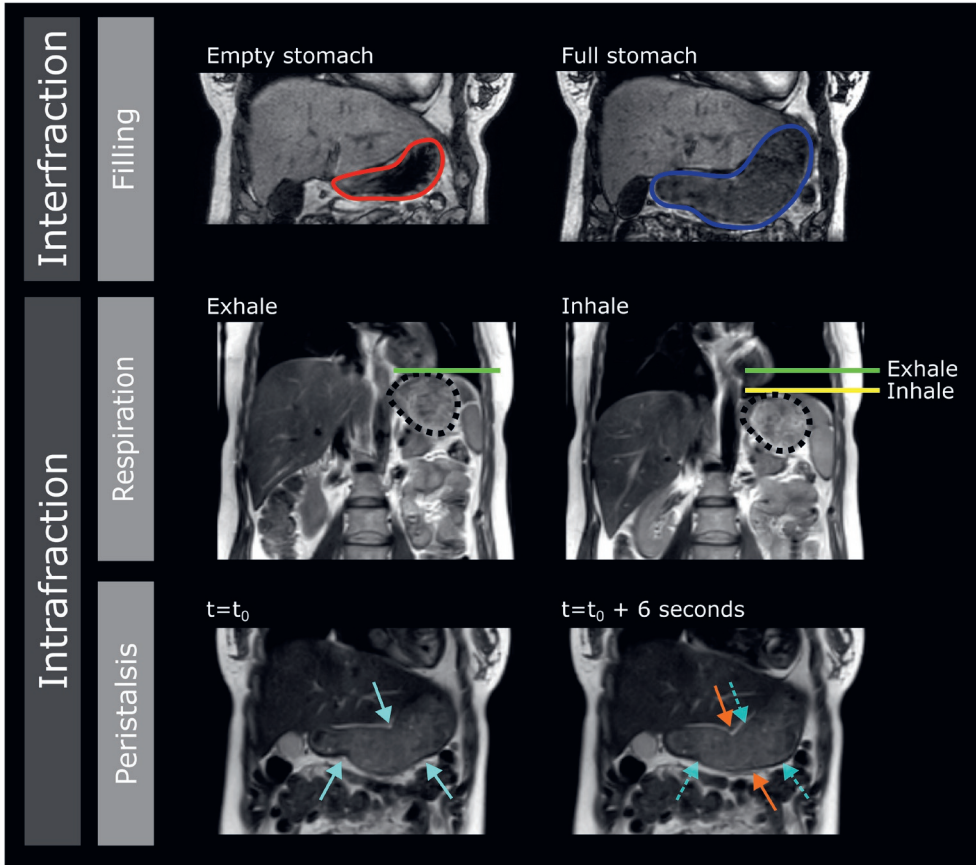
Coronal slices of magnetic resonance imaging (MRI) with examples of the stomach's interfractional and intrafractional changes in one healthy volunteer. Interfractional changes can be caused by stomach filling (red is an empty stomach, and blue is a full stomach). Intrafractional changes can be caused by various factors, including respiration or peristalsis. Respiratory motion is depicted by the change in the left diaphragm dome position on exhale (green line) and inhale (yellow line) phase images from a 4D scan, with the stomach indicated by the black dashed line. Peristalsis is demonstrated by the change in stomach wall contractions over time with the location of peristaltic contractions at  $t=0$  (light blue arrows) and 6 seconds later (orange arrows).
